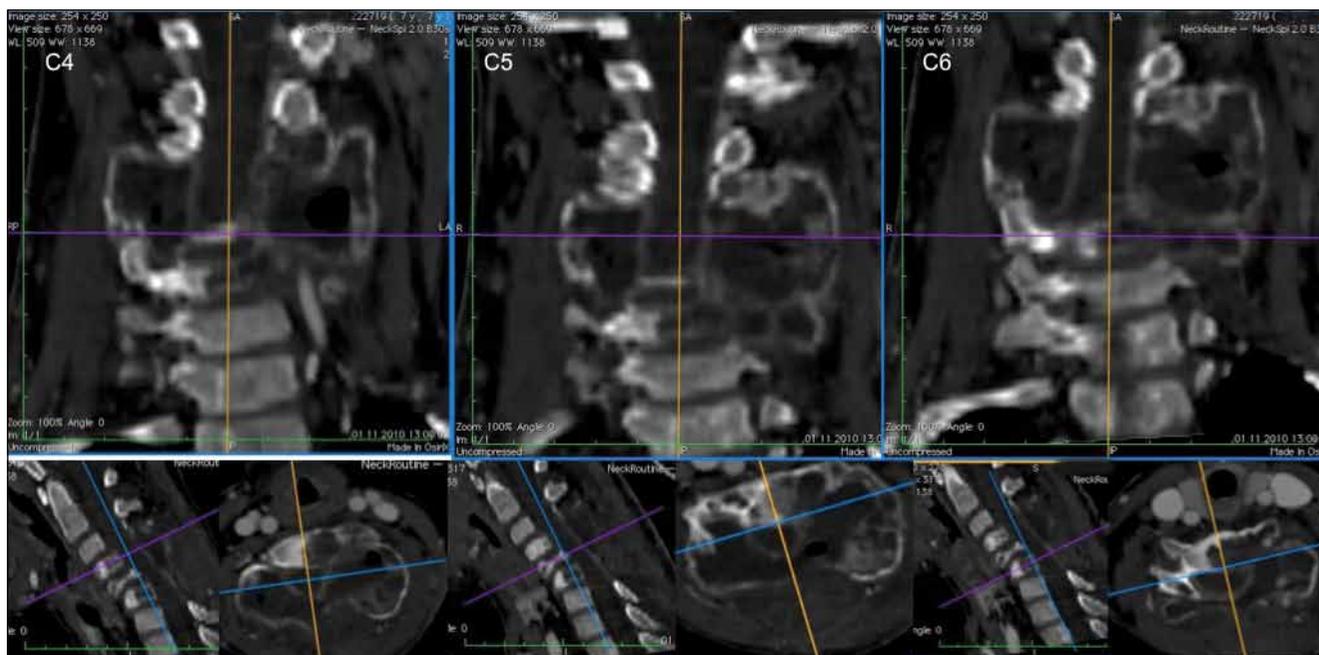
Preoperative axial CT, sagittal and coronal reformatted images revealed expansile spongy lesions in three vertebrae, collapse of the C5 and anterior angulation of the cervical spine.
